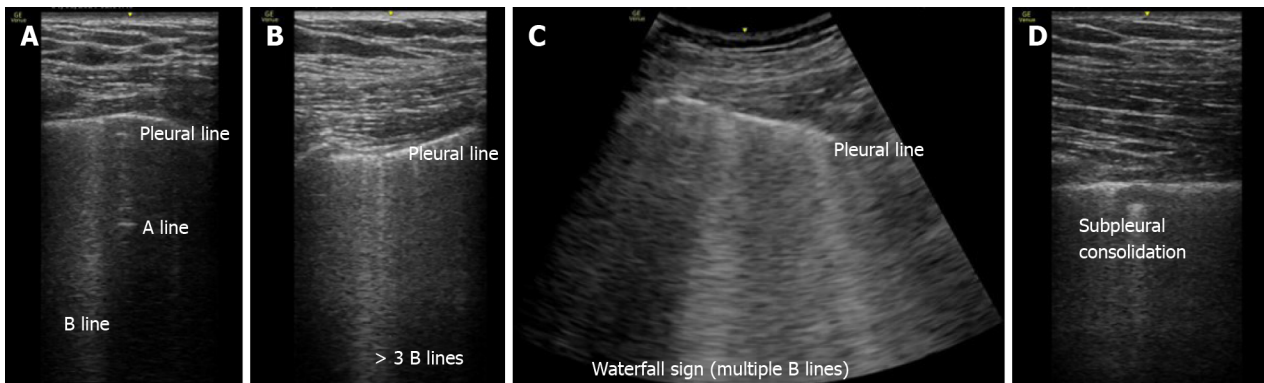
Images demonstrating the main changes in lung ultrasonography in coronavirus disease 2019 patients. A: Normal A-pattern with presence of 1 B line. B: Normal pleural line with presence of > 3 B lines. C: Irregular pleural line with coalescent B lines. D: Pleural involvement as sign of poor aeration.
